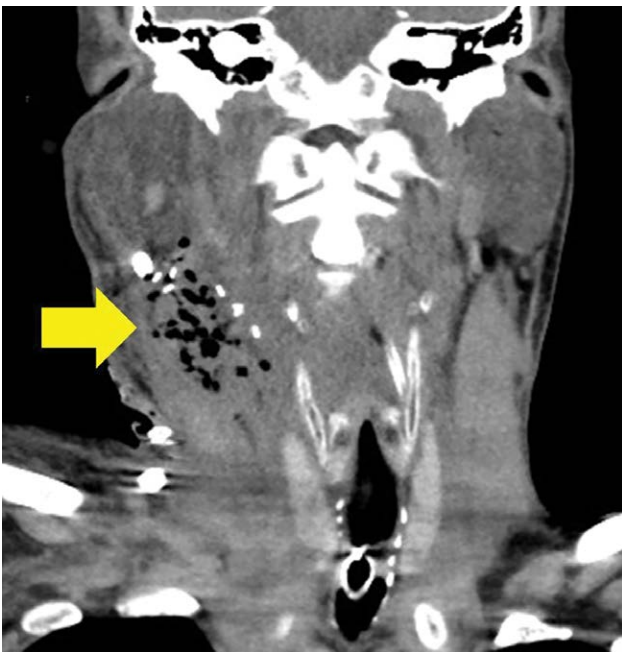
CT scan of head and neck on postoperative day 4. Yellow arrows indicate the presence of gas in the necrotic tissues.
